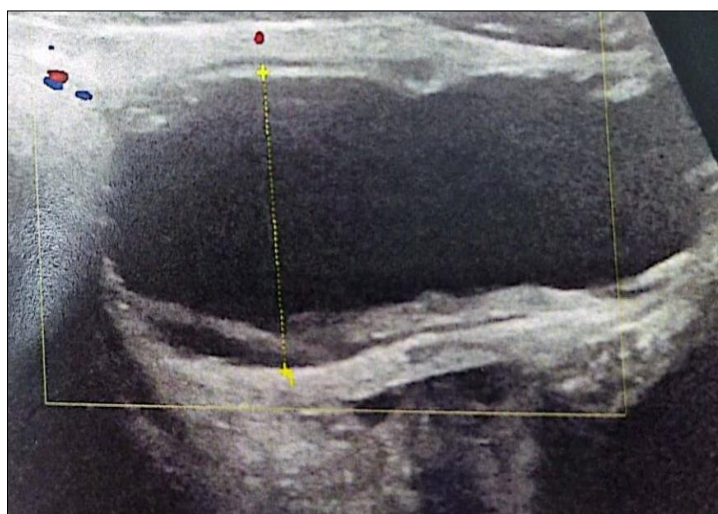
ultrasound image showing the hydrosalpinx
